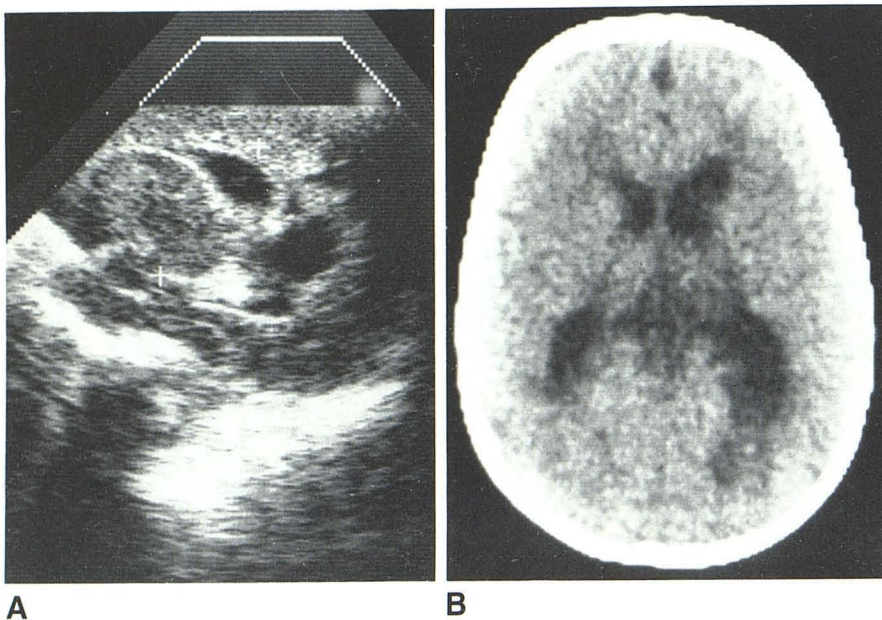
10-month-old infant with periventricular cysts. A, Angled sagittal sonogram shows large cyst close to trigone. B, Axial CT scan shows poorly defined low density in corresponding area.
